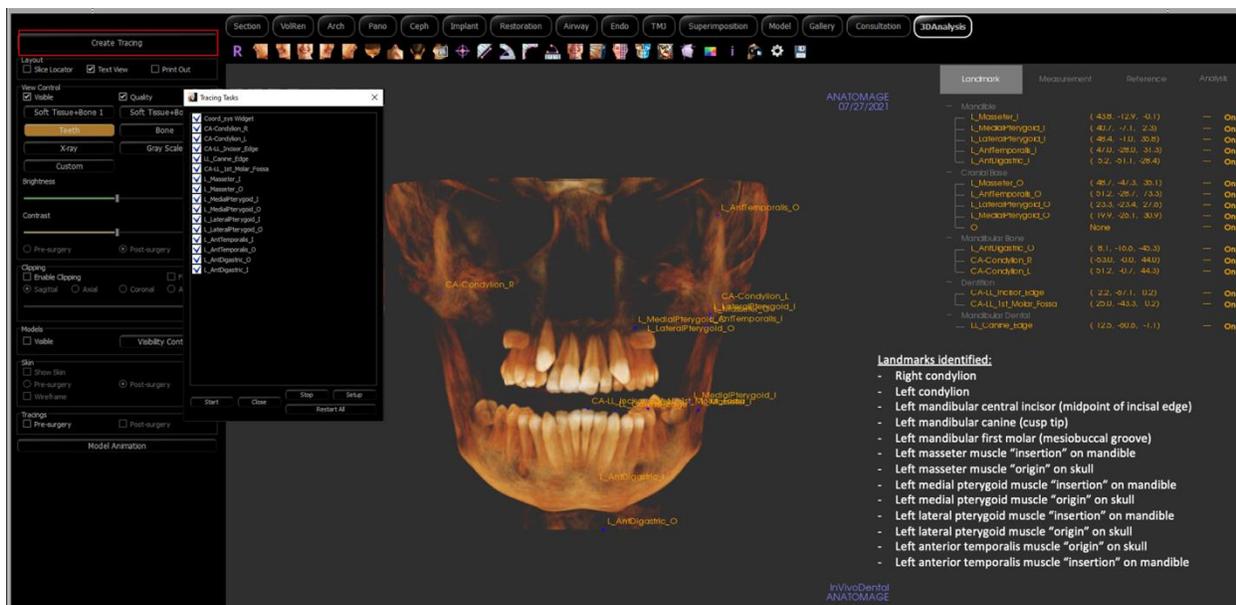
3D landmarks (blue points) identified on CBCT with InVivo Anatomage. Using 3DAnalysis feature, condyles, teeth, and insertions of muscles of mastication were identified.
